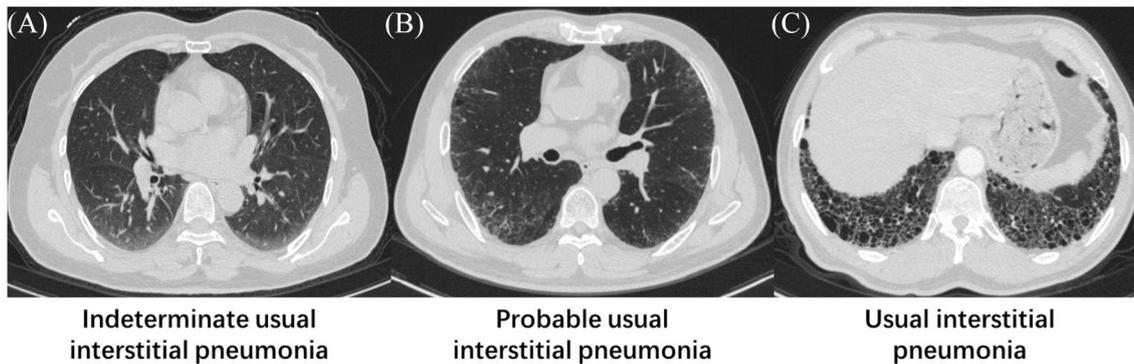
Representative interstitial lung disease patterns on computed tomography according to the criteria published by the American Thoracic Society/European Respiratory Society/Japanese Respiratory Society/Latin American Thoracic Association in 2018. (A) Indeterminate usual interstitial pneumonia, subpleural predominant ground-glass abnormality. (B) Possible usual interstitial pneumonia, subpleural and basal predominant reticular abnormality, without honeycombing. (C) Usual interstitial pneumonia, subpleural and basal predominant honeycombing abnormality.
